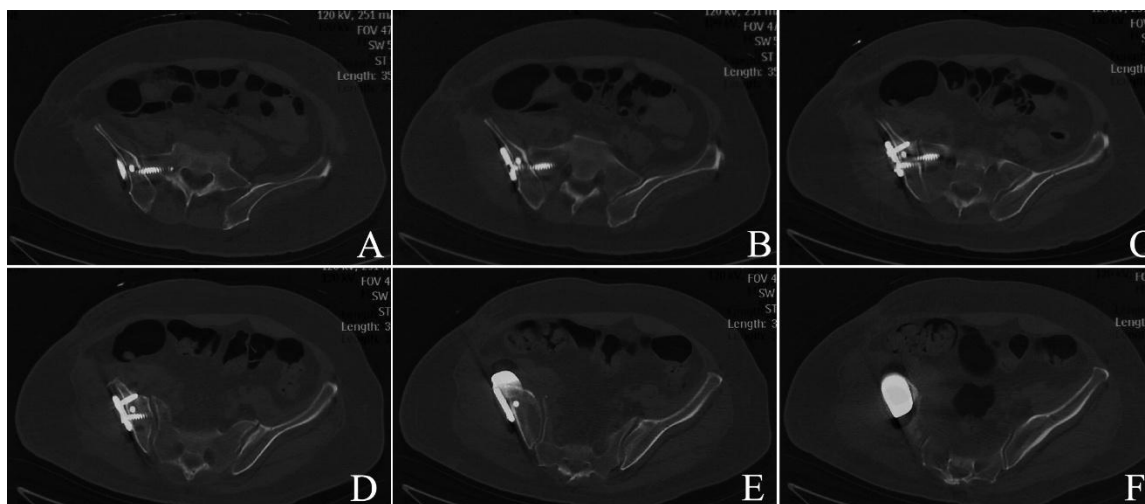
A-F Results of CT scan at 6-month follow-up from a 59-year-old male receiving type II + III resection of a pelvic chondrosarcoma and reconstruction with 3D-printed hemipelvic endoprosthesis. Axial CT films showed that there was no recurrence, and that the fixation screws precisely went through the sacroiliac joint into the sacral vertebra, and that the widths of both sacroiliac gaps were generally equal.
